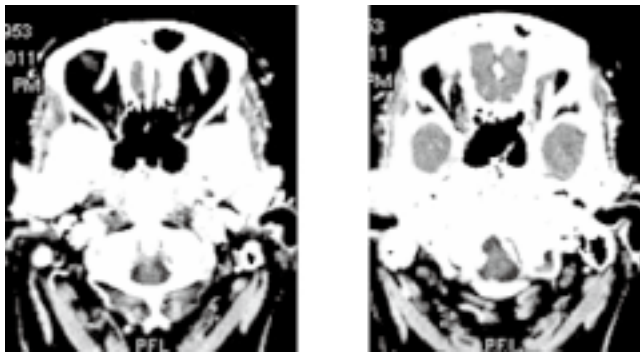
CT angiogram shows bilateral dilated/prominent superior ophthalmic veins
